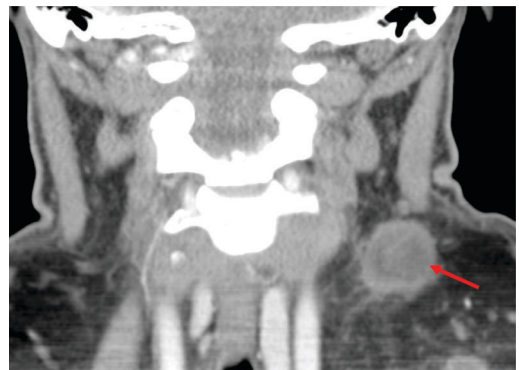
CT neck demonstrating 3 cm left jugular chain/posterior triangle mass (see arrow).
